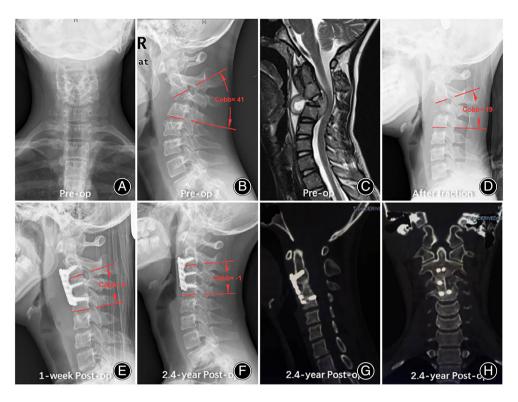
A 22-year-old female with cervical tuberculosis presented with worsening cervical pain, dysphagia, stridor, and weakness of extremities. The lateral cervical X-ray (A, B) showed severe kyphosis of 41° at C2-4, and C3 is the apical vertebra which was destroyed by the lesion. The MRI indicated clearly bony destruction located in the C3 vertebrae body, and a large retropharyngeal abscess anterior to C2-4 vertebra which also connected with the spinal canal and the lesion caused significant compression of the spinal cord (C). The lateral radiograph showed a recovering cervical alignment after skull traction, the kyphosis was relieved to 19° (D), and it was further corrected to 5° after surgery (E). The X-ray and three-dimensional CT at the final follow-up indicated the cervical sagittal alignment maintained well, and the solid bone fusion was achieved without internal fixation related complications (F–H).
